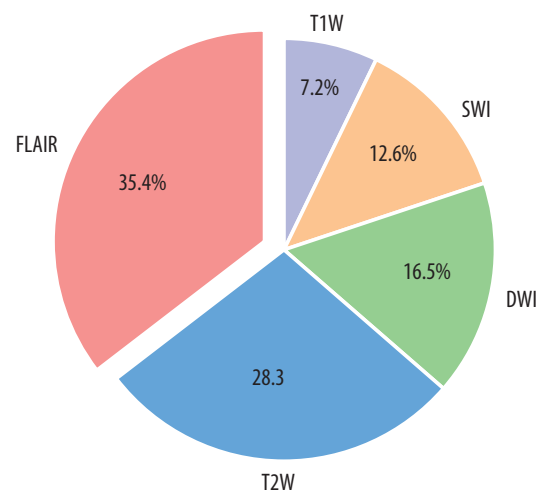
Distribution of selected features across MRI sequences and feature types
